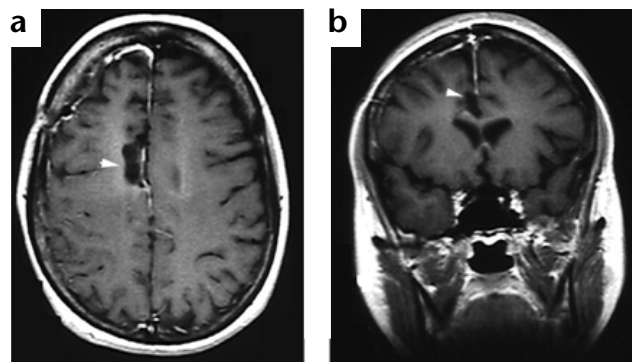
MRI scans showing D.L.'s lesion. (a) Horizontal cross-section at the level of the cingulate sulcus. (b) Coronal view of caudal ACC. The lesioned area in the right hemisphere is indicated by an arrowhead, and lies on the left side of the scan. The lesion excludes the overlying supplementary motor area, and extends down to the corpus callosum. The caudal extent of the lesion coincides with the portion of the cingulate motor area reportedly involved in manual-response control. In the coronal view, the double-sulcus pattern can be seen. The paracingulate sulcus is intact, but the lesion covers both the dorsal and ventral banks of the cingulate sulcus and the surrounding gyral surface.
